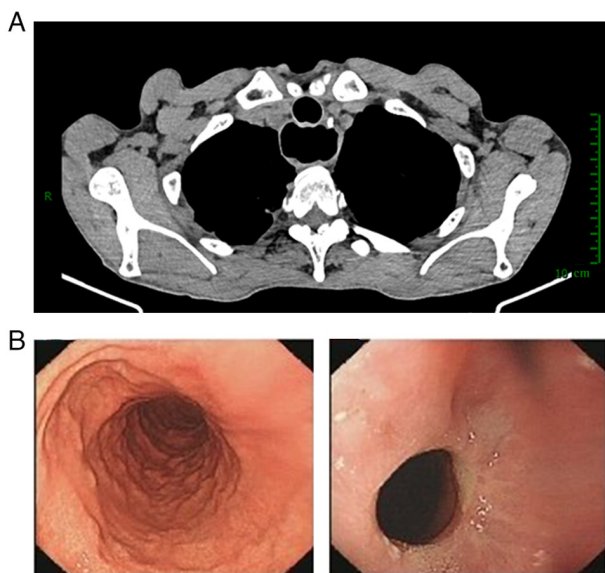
Follow-up results of CT scan and endoscopy. (A) A CT scan performed in October 2023 revealed no recurrence or metastasis. (B) Endoscopy performed in December 2023 revealed no recurrence. CT, computed tomography.
